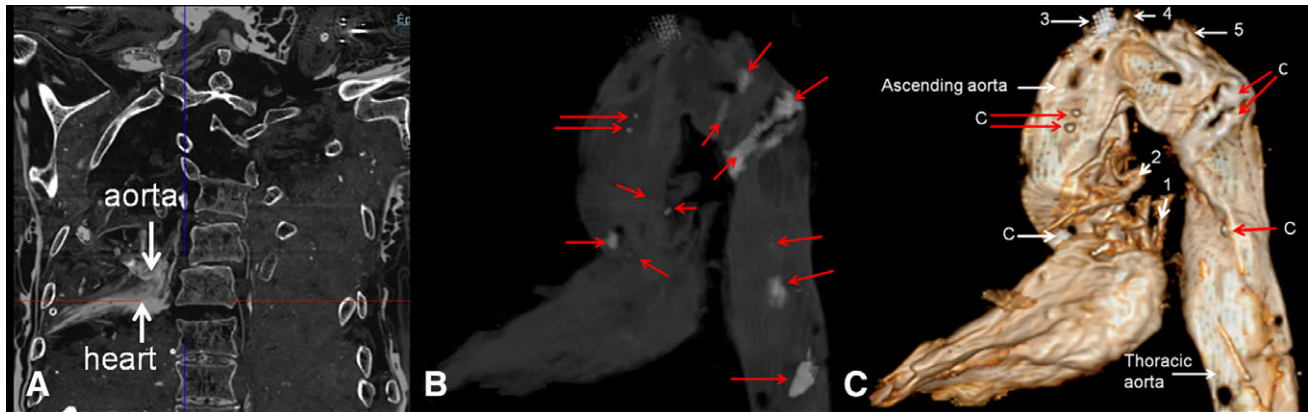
Heart 3D CT scan. (A) 3D CT scan, frontal slice through the thoracic cavity. (B) Maximal intensity projection and multiple calcifications along aorta. (C) Three-dimensional reconstruction of pericardium and aorta. 1. Right auricle. 2. Pulmonary arteries. 3. Brachiocephalic artery. 4. Common carotid artery. 5. Left subclavian artery. C: calcifications.
